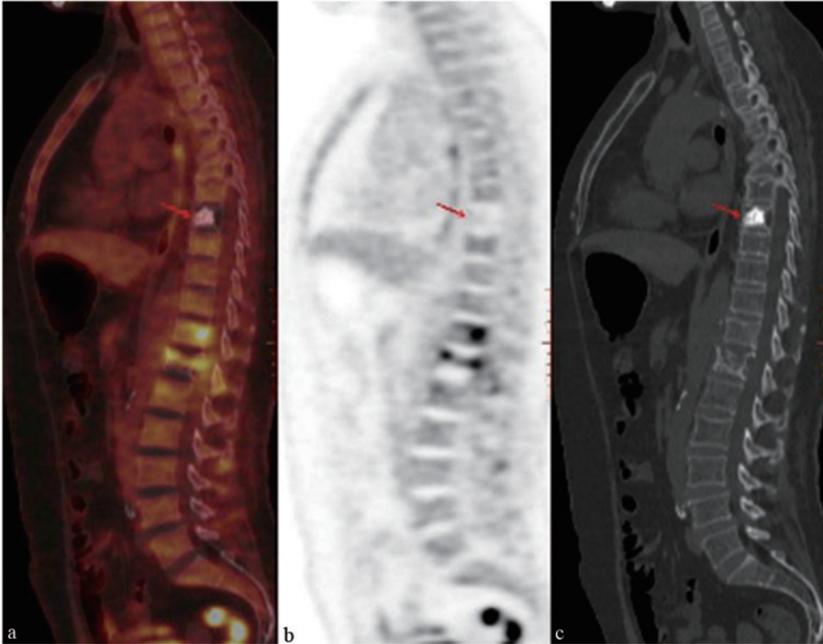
Positron emission tomography-computed tomography (PET-CT) images. a–c: Fence-like trabecular bone, irregular density shadows, and reduced F-18 fluorodeoxyglucose (FDG) uptake or defects (bone island), in contrast to bone metastases, which present with high FDG uptake.
